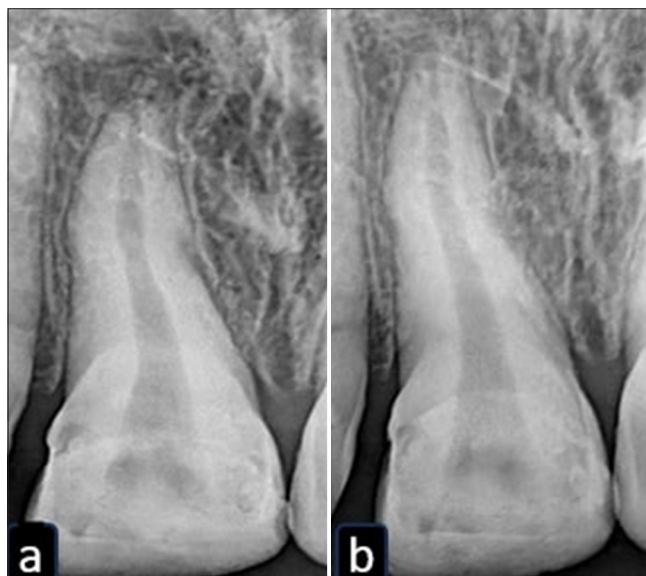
Radiograph showing no changes # 11 after (a) 1 week and (b) 1 month.
